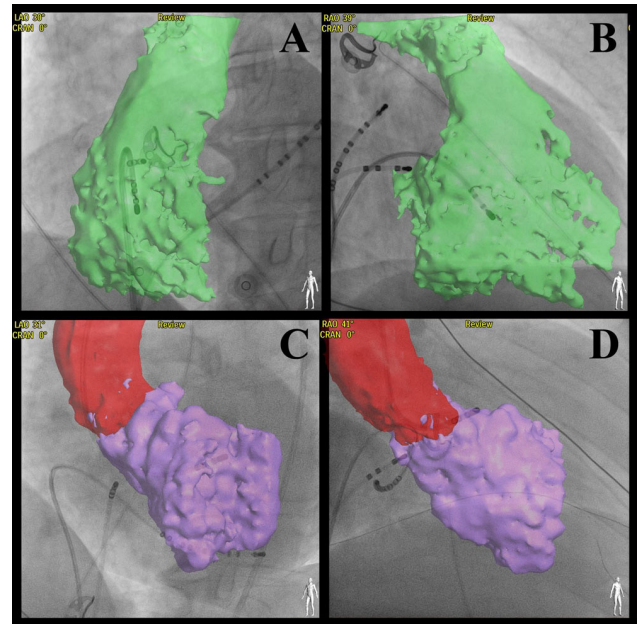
Comparison of CT and 3DRA raw data measurements. (A, B) Picture of the body of the right ventricle and pulmonary valve, as well as part of the pulmonary artery, A - 3DRA, B - CT, (C, D) Picture of the body of the left ventricle and aortic bulbus, as well as part of the ascending aorta, C - 3DRA, D - CT. 3DRA - 3D rotational angiography, CT - Computed tomography
